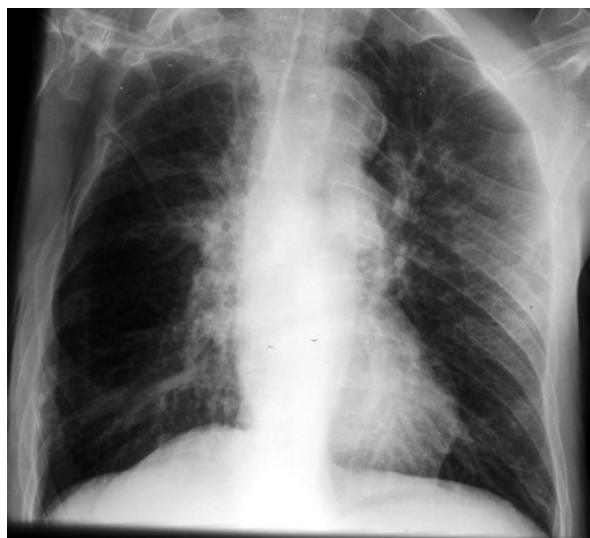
Chest X-ray showed right hyperlucent hemithorax
